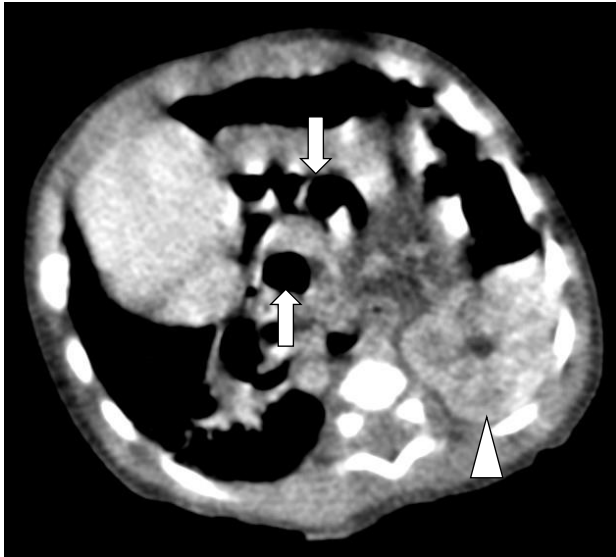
Chest CT scan at 14 days old. Axial image in soft tissue window setting revealed herniated bowel loops (arrows) occupying left hemithorax. The displaced left kidney (arrowhead) is seen posteriorly
